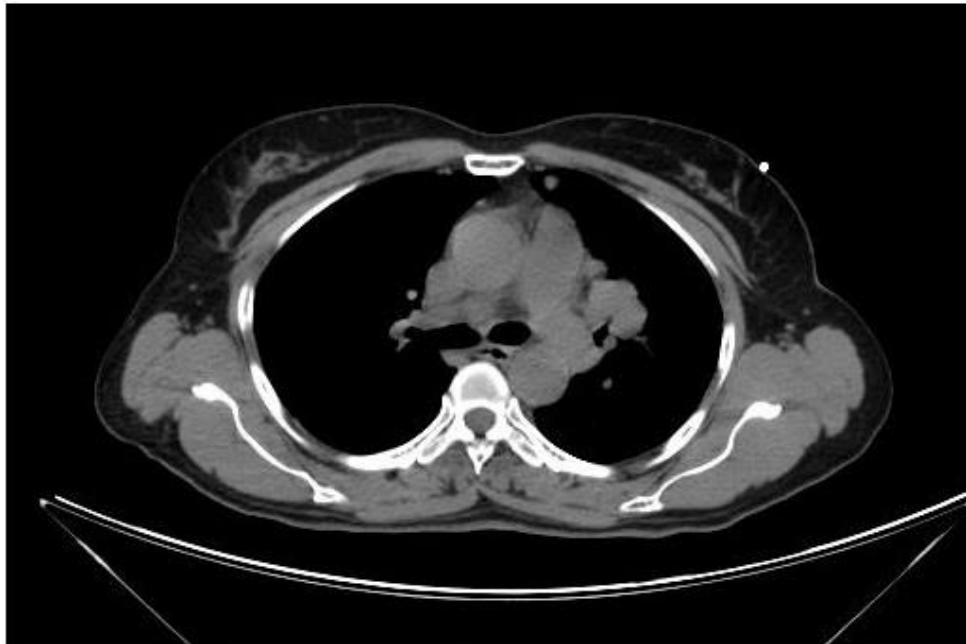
Image showing axial plane of Computed Tomography performed at standard dose of 325 mAs.
